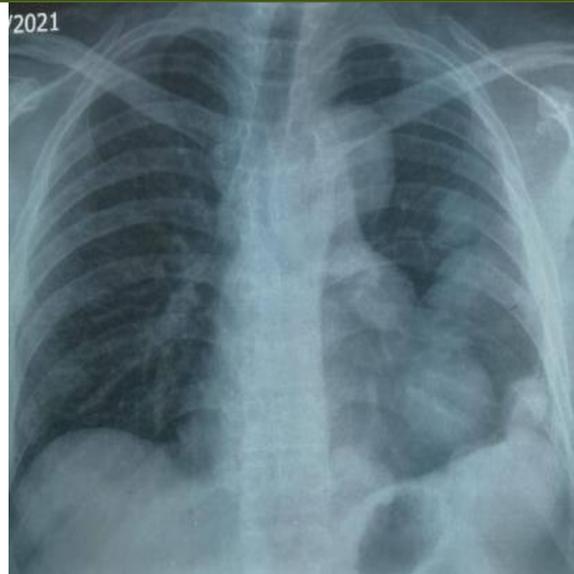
Frontal chest radiograph. Left mediastinal and pulmonary opacities
